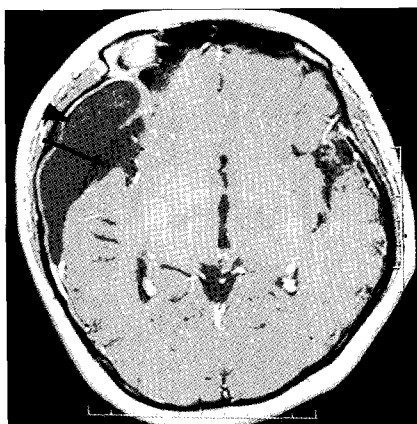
Gadolinium enhanced axial MR image demonstrating hypointense arachnoid cyst (arrow) with crescent mass (arrowhead).
